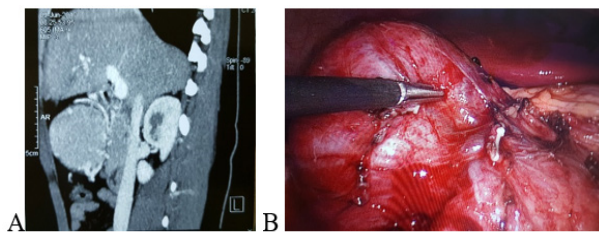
Open surgery to treat Castleman disease (A,B: Lesions on CT scan and during surgery; C: Lesion from complete resection of the tumor) (Patient LTHA).
